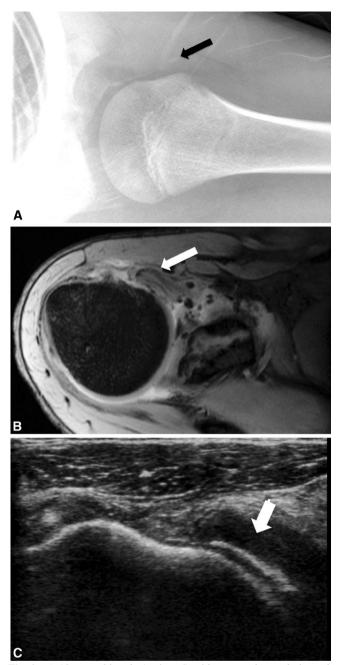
A 12-year-old male (patient 6) with acute subscapularis avulsion 2 weeks before presentation at our clinic. a Axillary radiograph shows a small avulsion fragment anterior to the humeral head.(*arrow*). b Fat-suppressed T1-weighted image from an MR arthrogram demonstrates the avulsed tendon (*arrow*). c Transverse image from an ultrasound shows the subscapularis tendon avulsion (*arrow*).
